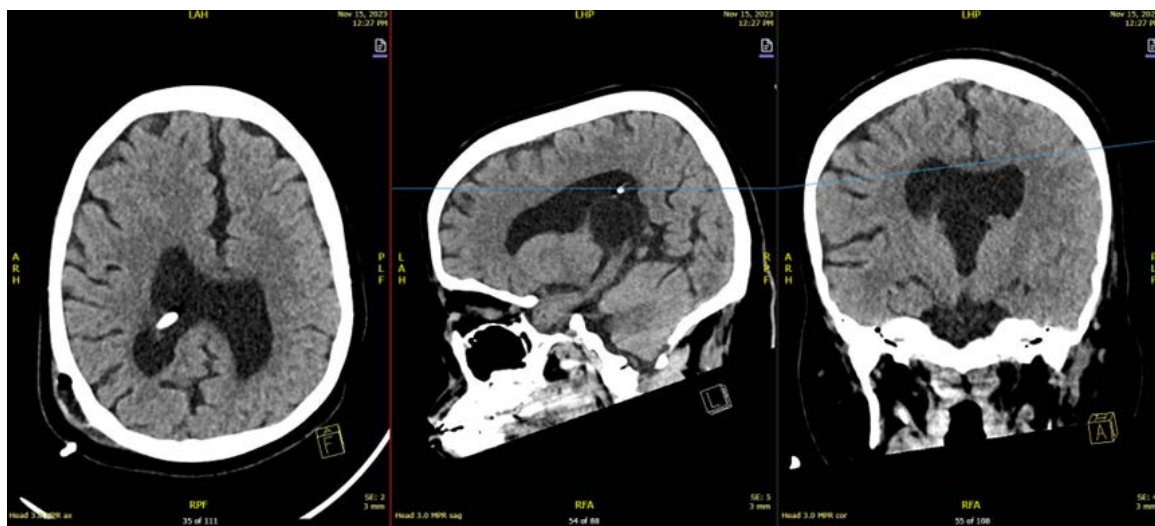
Postoperative non-contrast computed tomography (CT) of the brain demonstrating ventricular catheter placement and ventricular changes. (A) Coronal, (B) sagittal, and (C) axial images showing interval replacement of the ventriculoperitoneal shunt with a ventricular catheter with the catheter tip located in the right parietal horn. There is mild improvement of chronic supratentorial ventricular dilatation without evidence of transependymal edema. No intra-axial or extra-axial hemorrhage is identified. A known midline cystic lesion in the pineal region demonstrates interval increase in size with stable Chiari type I malformation and tonsillar ectopia.
